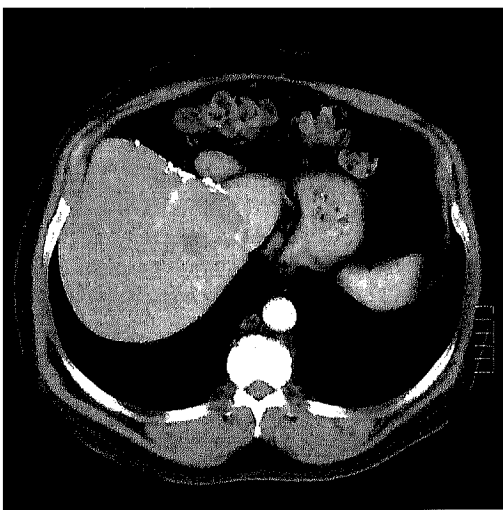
Computed tomogram of a lesion before treatment
